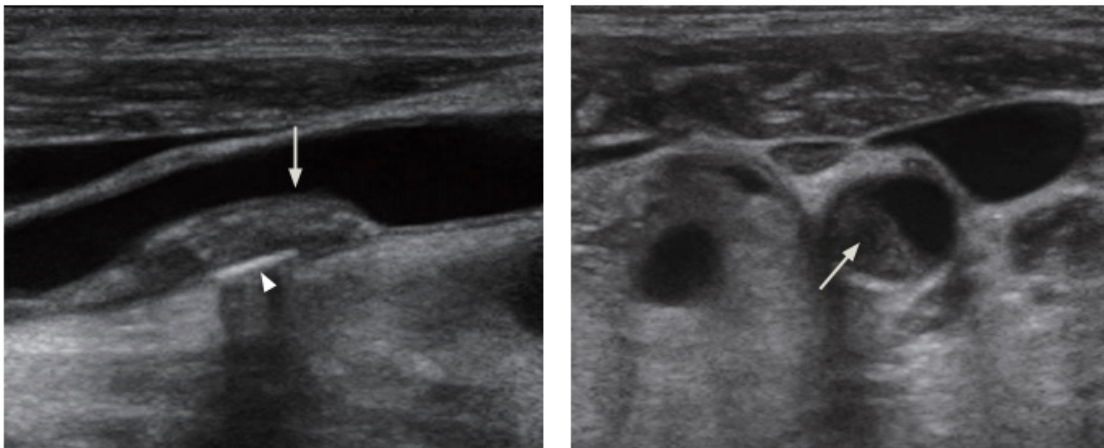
A gray-scale long-axis ultrasound image of the distal common carotid artery (left). Calcification (arrowhead) and plaque (arrow) can be clearly visualized within the artery. A short-axis ultrasound image of the distal common carotid artery (right). The more lucent plaque (arrow) is typically associated with higher risk of plaque rupture. Figure adapted from Lee et al.²⁹
